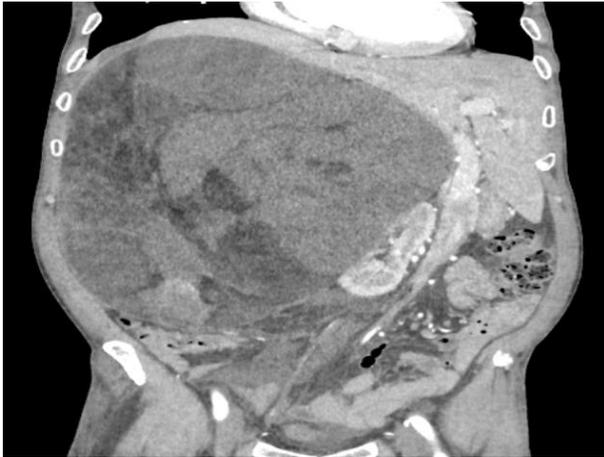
Abdominal and pelvic CT scan showed a huge limited mass occupying the right hemi-abdomen, measuring 14x19x20cm.
